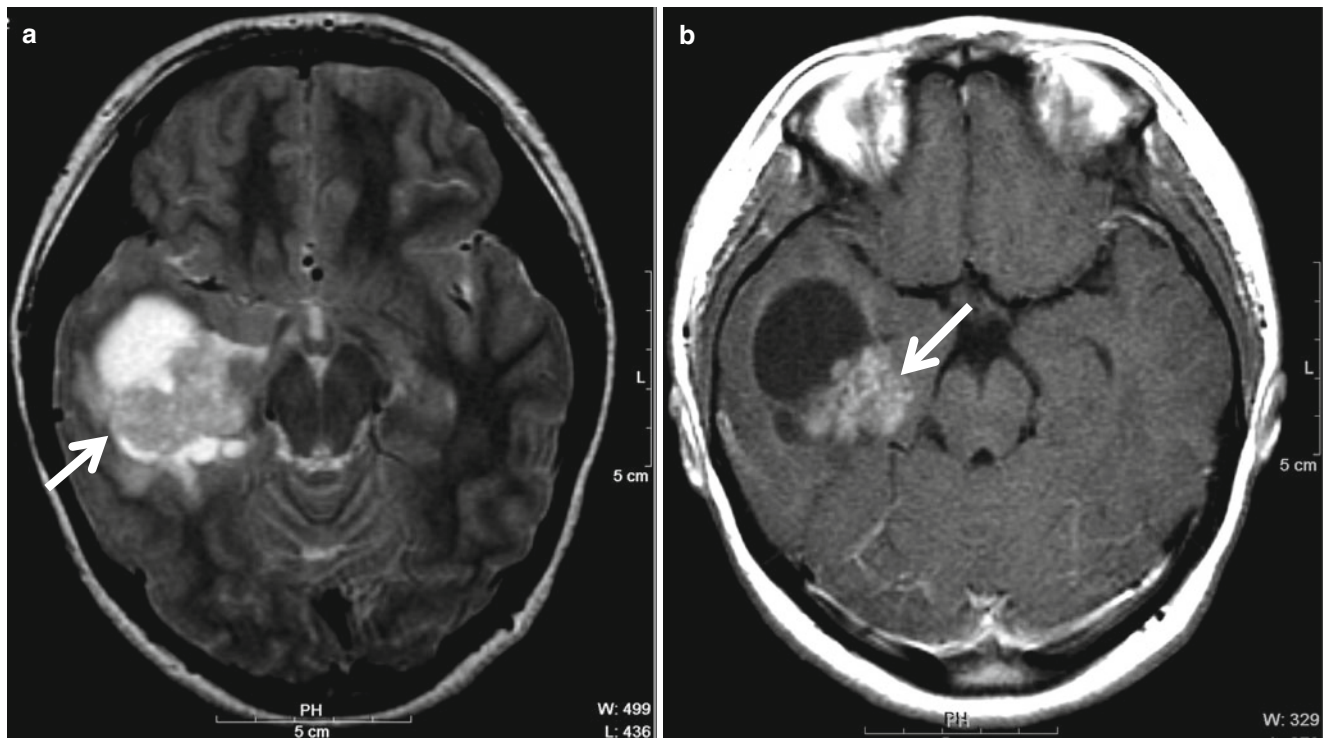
Ganglioglioma in a 13-year-old girl. (a) T2-weighted image shows solid and cystic mass in the right temporal lobe (*arrow*). (b) The solid portion is heterogeneously enhanced (*arrow*), surrounded by mild edema on a postcontrast image
